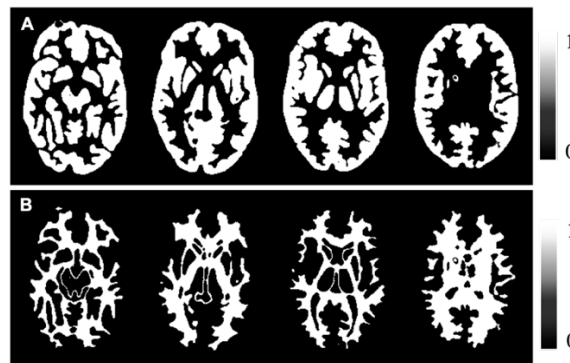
(A) GM and (B) WM masks (binary images) obtained by segmenting the CT image using in-house MATLAB® scripts.
